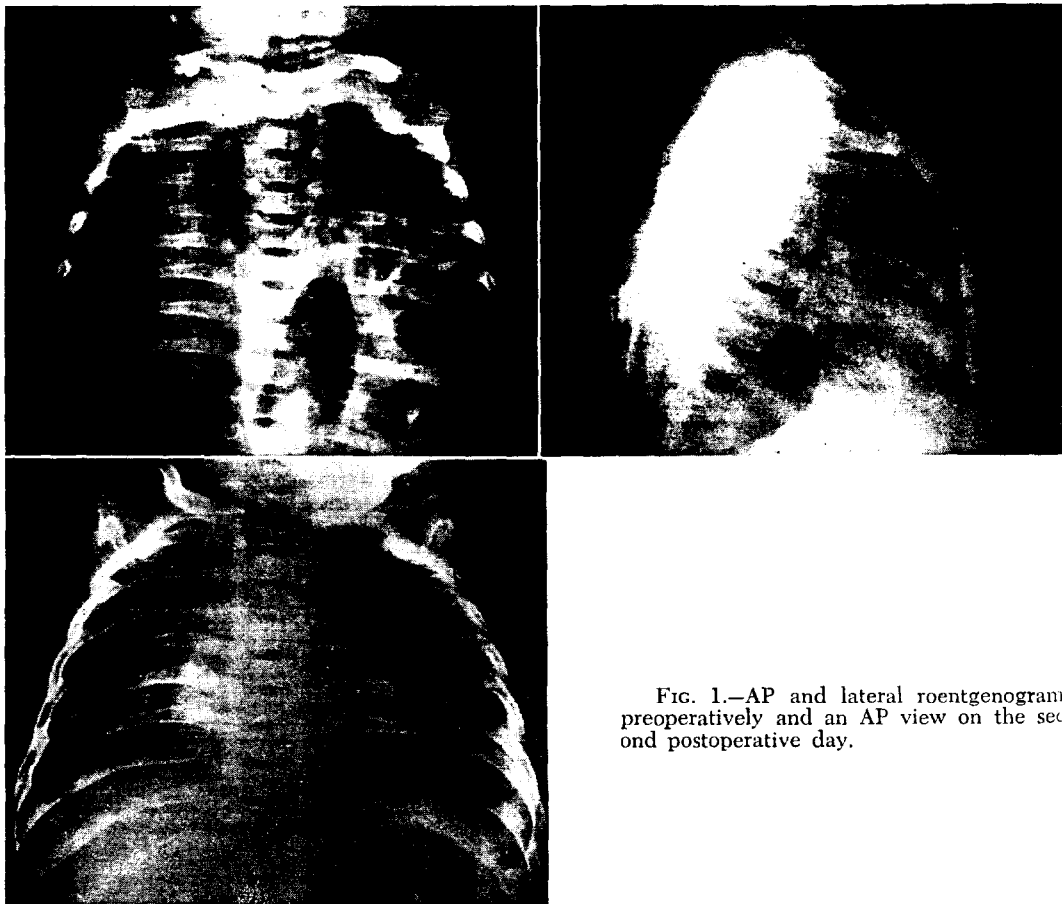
AP and lateral roentgenograms preoperatively and an AP view on the second postoperative day.
